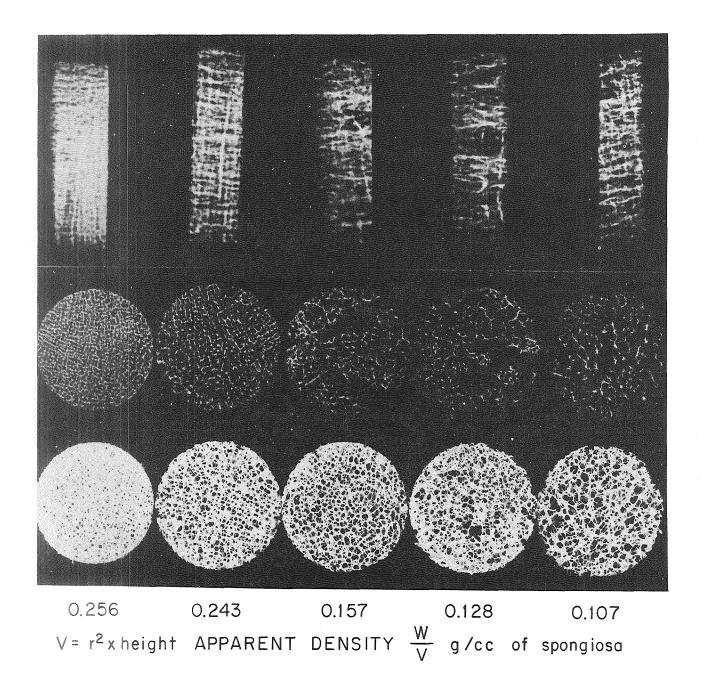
Coin-shaped segments of the first lumbar vertebra obtained from five autopsy subjects, showing five levels of reduction of bone mass. Roentgenogram of the segments: (Top) end views showing progressive increase in diameter and mass of the vertical bone trabeculae; (middle) vertical view showing the attenuation of the horizontal trabecular structure and increase in *diameter* of the vertical bone trabeculae; (bottom) photograph of the fat-free dry trabecular segments showing the progressive increase in volume of *spaces* occupied by soft parts. Note that when the apparent density falls below 0.243, the attenuation of the structure is associated with reinforcement of the vertical trabecular bone. Thus, bone remodeling, removal, and reconstruction occur when osteoporosis develops.
